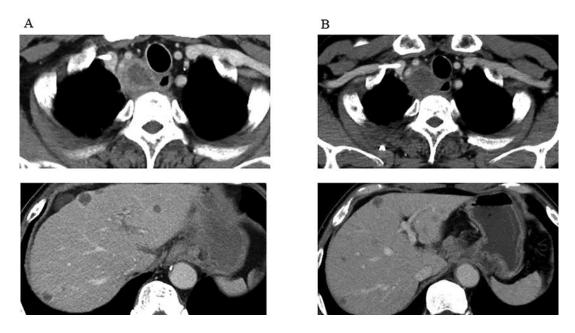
Baseline computed tomography (CT) (A) and second follow-up CT (B) in case 1.
